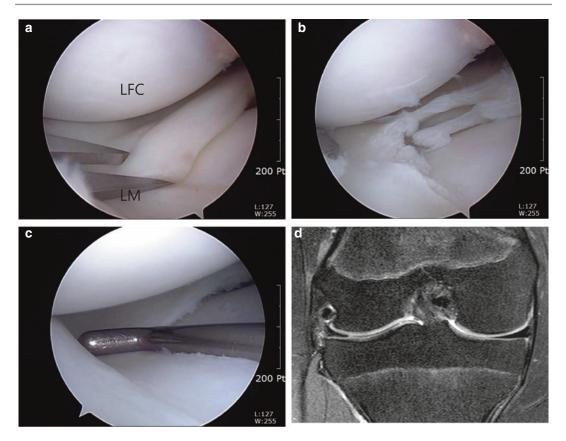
Arthroscopic findings show a the discoid meniscus was cut with an iris scissors through the anterolateral portal a meniscocapsular junction tear between the lateral meniscus anterior horn and the joint capsule. b Horizontal tear of discoid lateral meniscus can be seen. c Peripheral rim of discoid lateral meniscus was preserved the same size with midbody of medial meniscus. d coronal and sagittal magnetic resonance imaging shows complete healing of the tear site with a lateral meniscus of normal shape at 6 months' follow-up. (LFC lateral femoral condyle)
